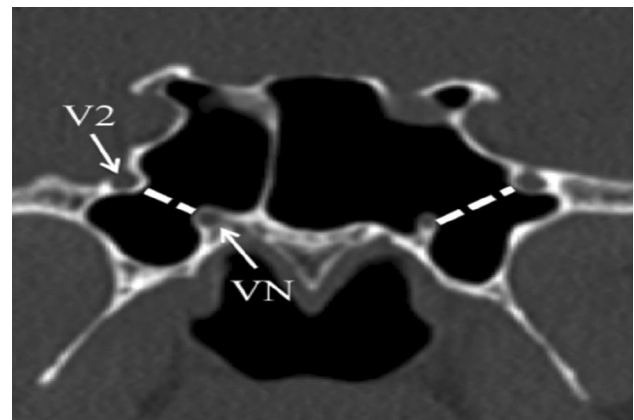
CT scan showing pneumatization of the lateral recess of the sphenoid sinus
